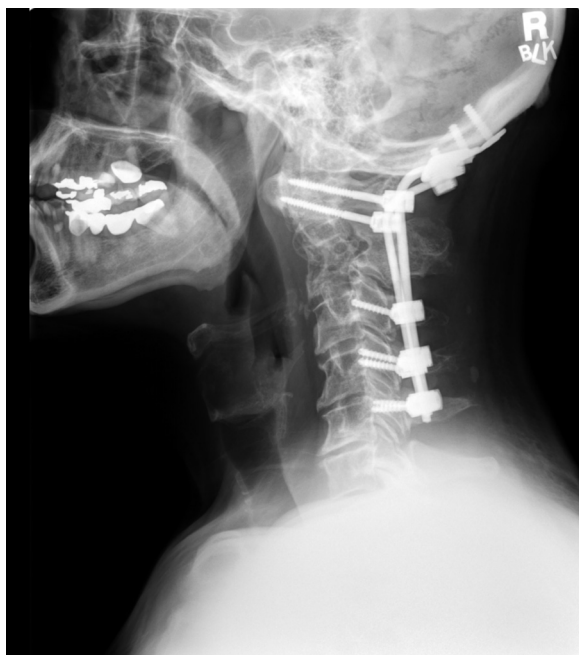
Final postoperative lateral X-ray demonstrating maintenance of cervical alignment without additional hardware related complications.
